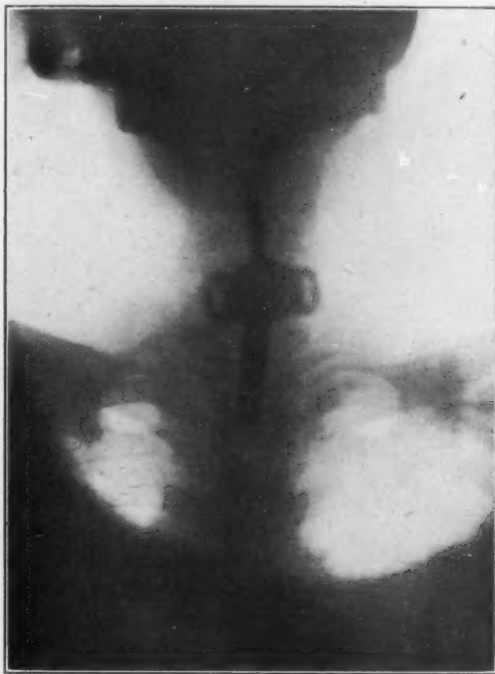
Esophageal intubation tube seen in position above and posterior to the tracheal canula. Cicatricial stenosis of the introitus esophagi in a man 60 years of age. Radiograph from the living patient by Dr. Russell H. Boggs.
